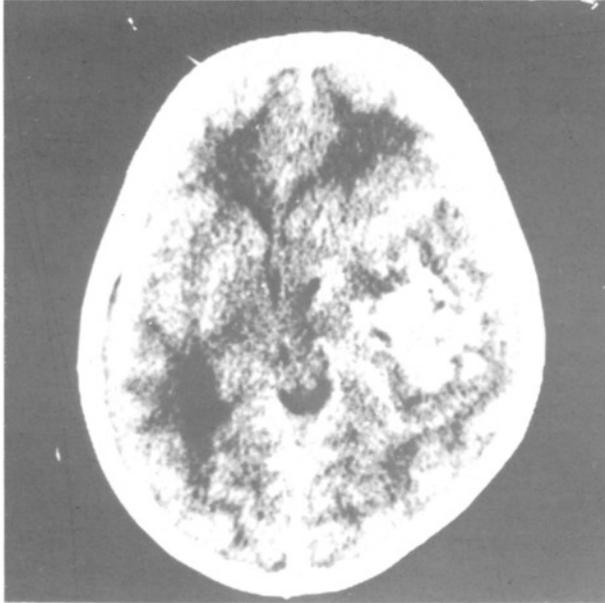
Non-contrast CT showing a right temporal mass with an haemorrhagic hyperdense center. The mass is heterogeneous in density and causing midline shift.
